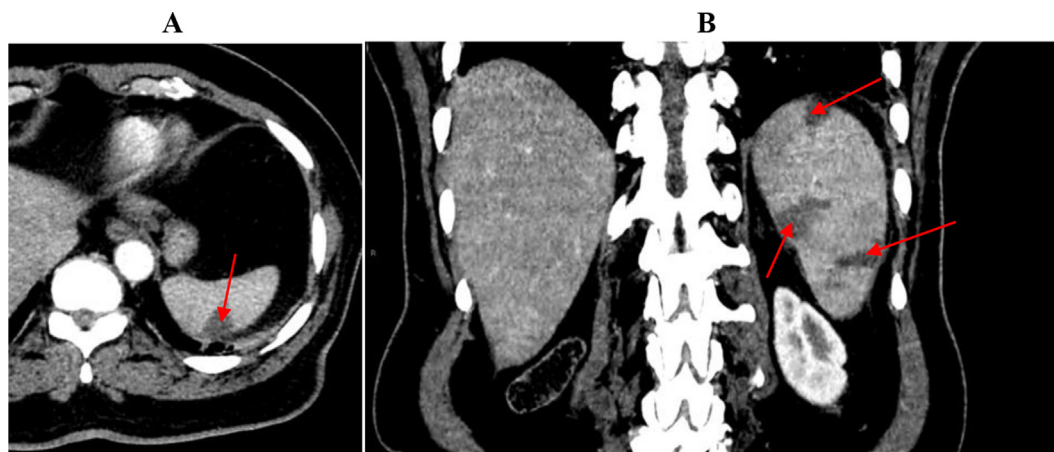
(A) Axial view of the computed tomography image of the abdomen showing splenic infarction (identified with red arrow). (B) Coronal view of the computed tomography image of the abdomen showing multiple splenic infarcts (identified with red arrows).
